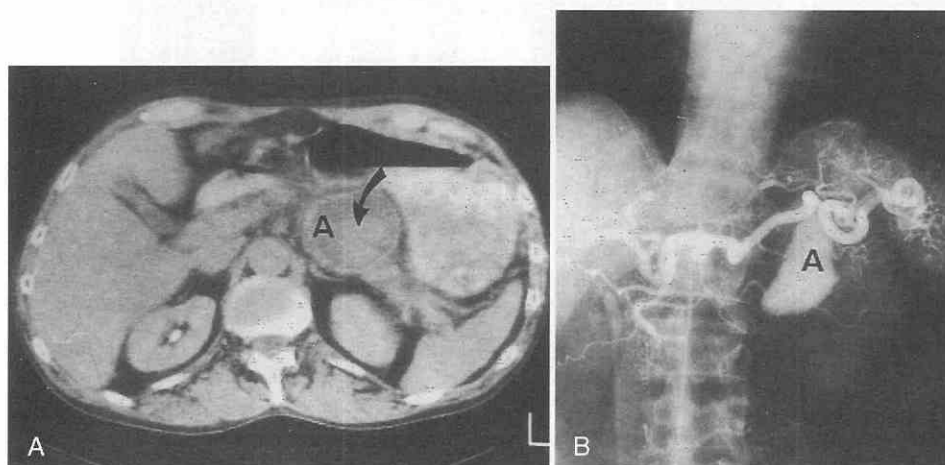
A, CT scan shows a low-density mass (A) with a central, high-density region (arrow) that represents a pseudoaneurysm of the splenic artery. B, Angiogram shows the large pseudoaneurysm (A) coming from the splenic artery.
